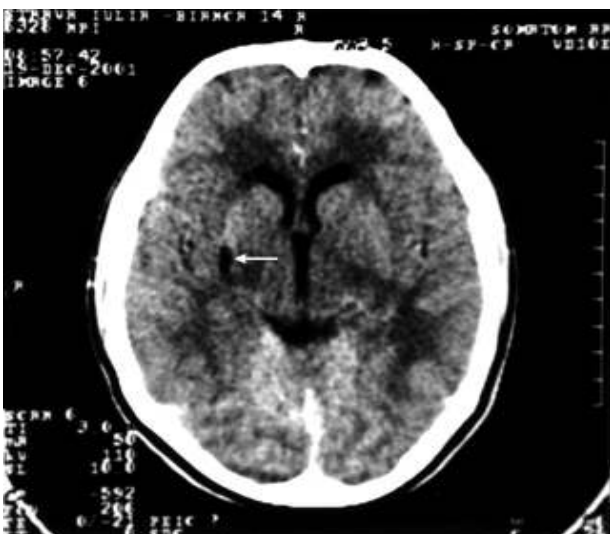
and Fig. 9. CT control exam 6 months after the first examination.
